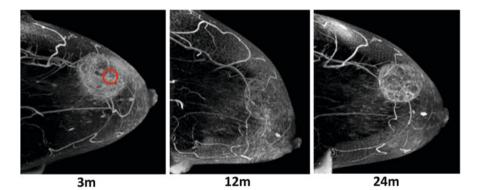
A case of postoperative development of the fatty breast, shown by MRI. A 3 m. B 12m. C 24 m. The white spot in the left image is the target tumor and an example of overtreatment (as of September 2013)
